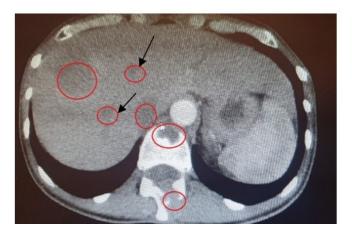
Imagine CT-Liver and bone metastases are visible
